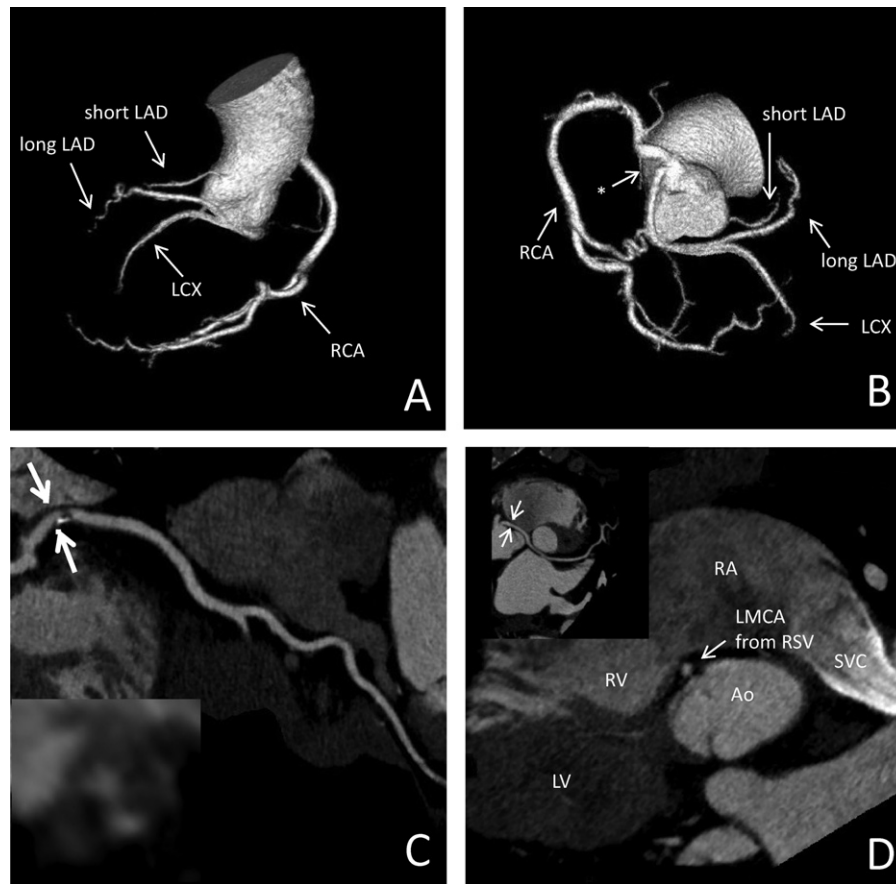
Non-invasive coronary angiography by multi-detector computed tomography. (A) and (B) Shaded surface display of the coronary tree shows the short left anterior descending artery originates from the left sinus of valsalva. The left main coronary artery with the long left anterior descending artery originates from the right sinus of valsalva. The origin of the left main coronary artery is indicated by '*'. The right coronary artery originates from a common origin. (C) Curved planar-reformatted display of the right coronary artery with a cross-sectional view shows spotty calcification and low attenuation plaque of the culprit lesion. (D) Curved planar-reformatted display of the left main coronary artery with a cross-sectional view shows an epicardial course on the right ventricle around the aortic root. LAD, left anterior descending artery; LCX, left circumflex artery; RCA, right coronary artery; LMCA, left main coronary artery; RSV, right sinus of valsalva; RA, right atrium; SVC, superior vena cava; RV, right ventricle; Ao, aorta; LV, left ventricle.
